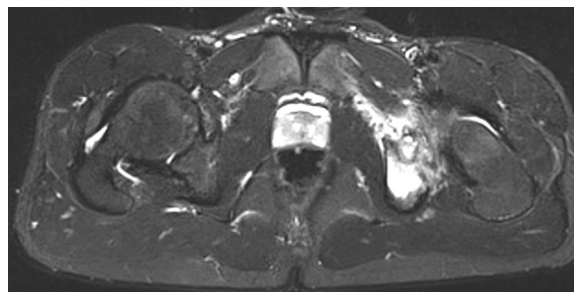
A fat-suppressed T2-weighted image shows diffuse edema from the adjacent muscle and bone marrow.
